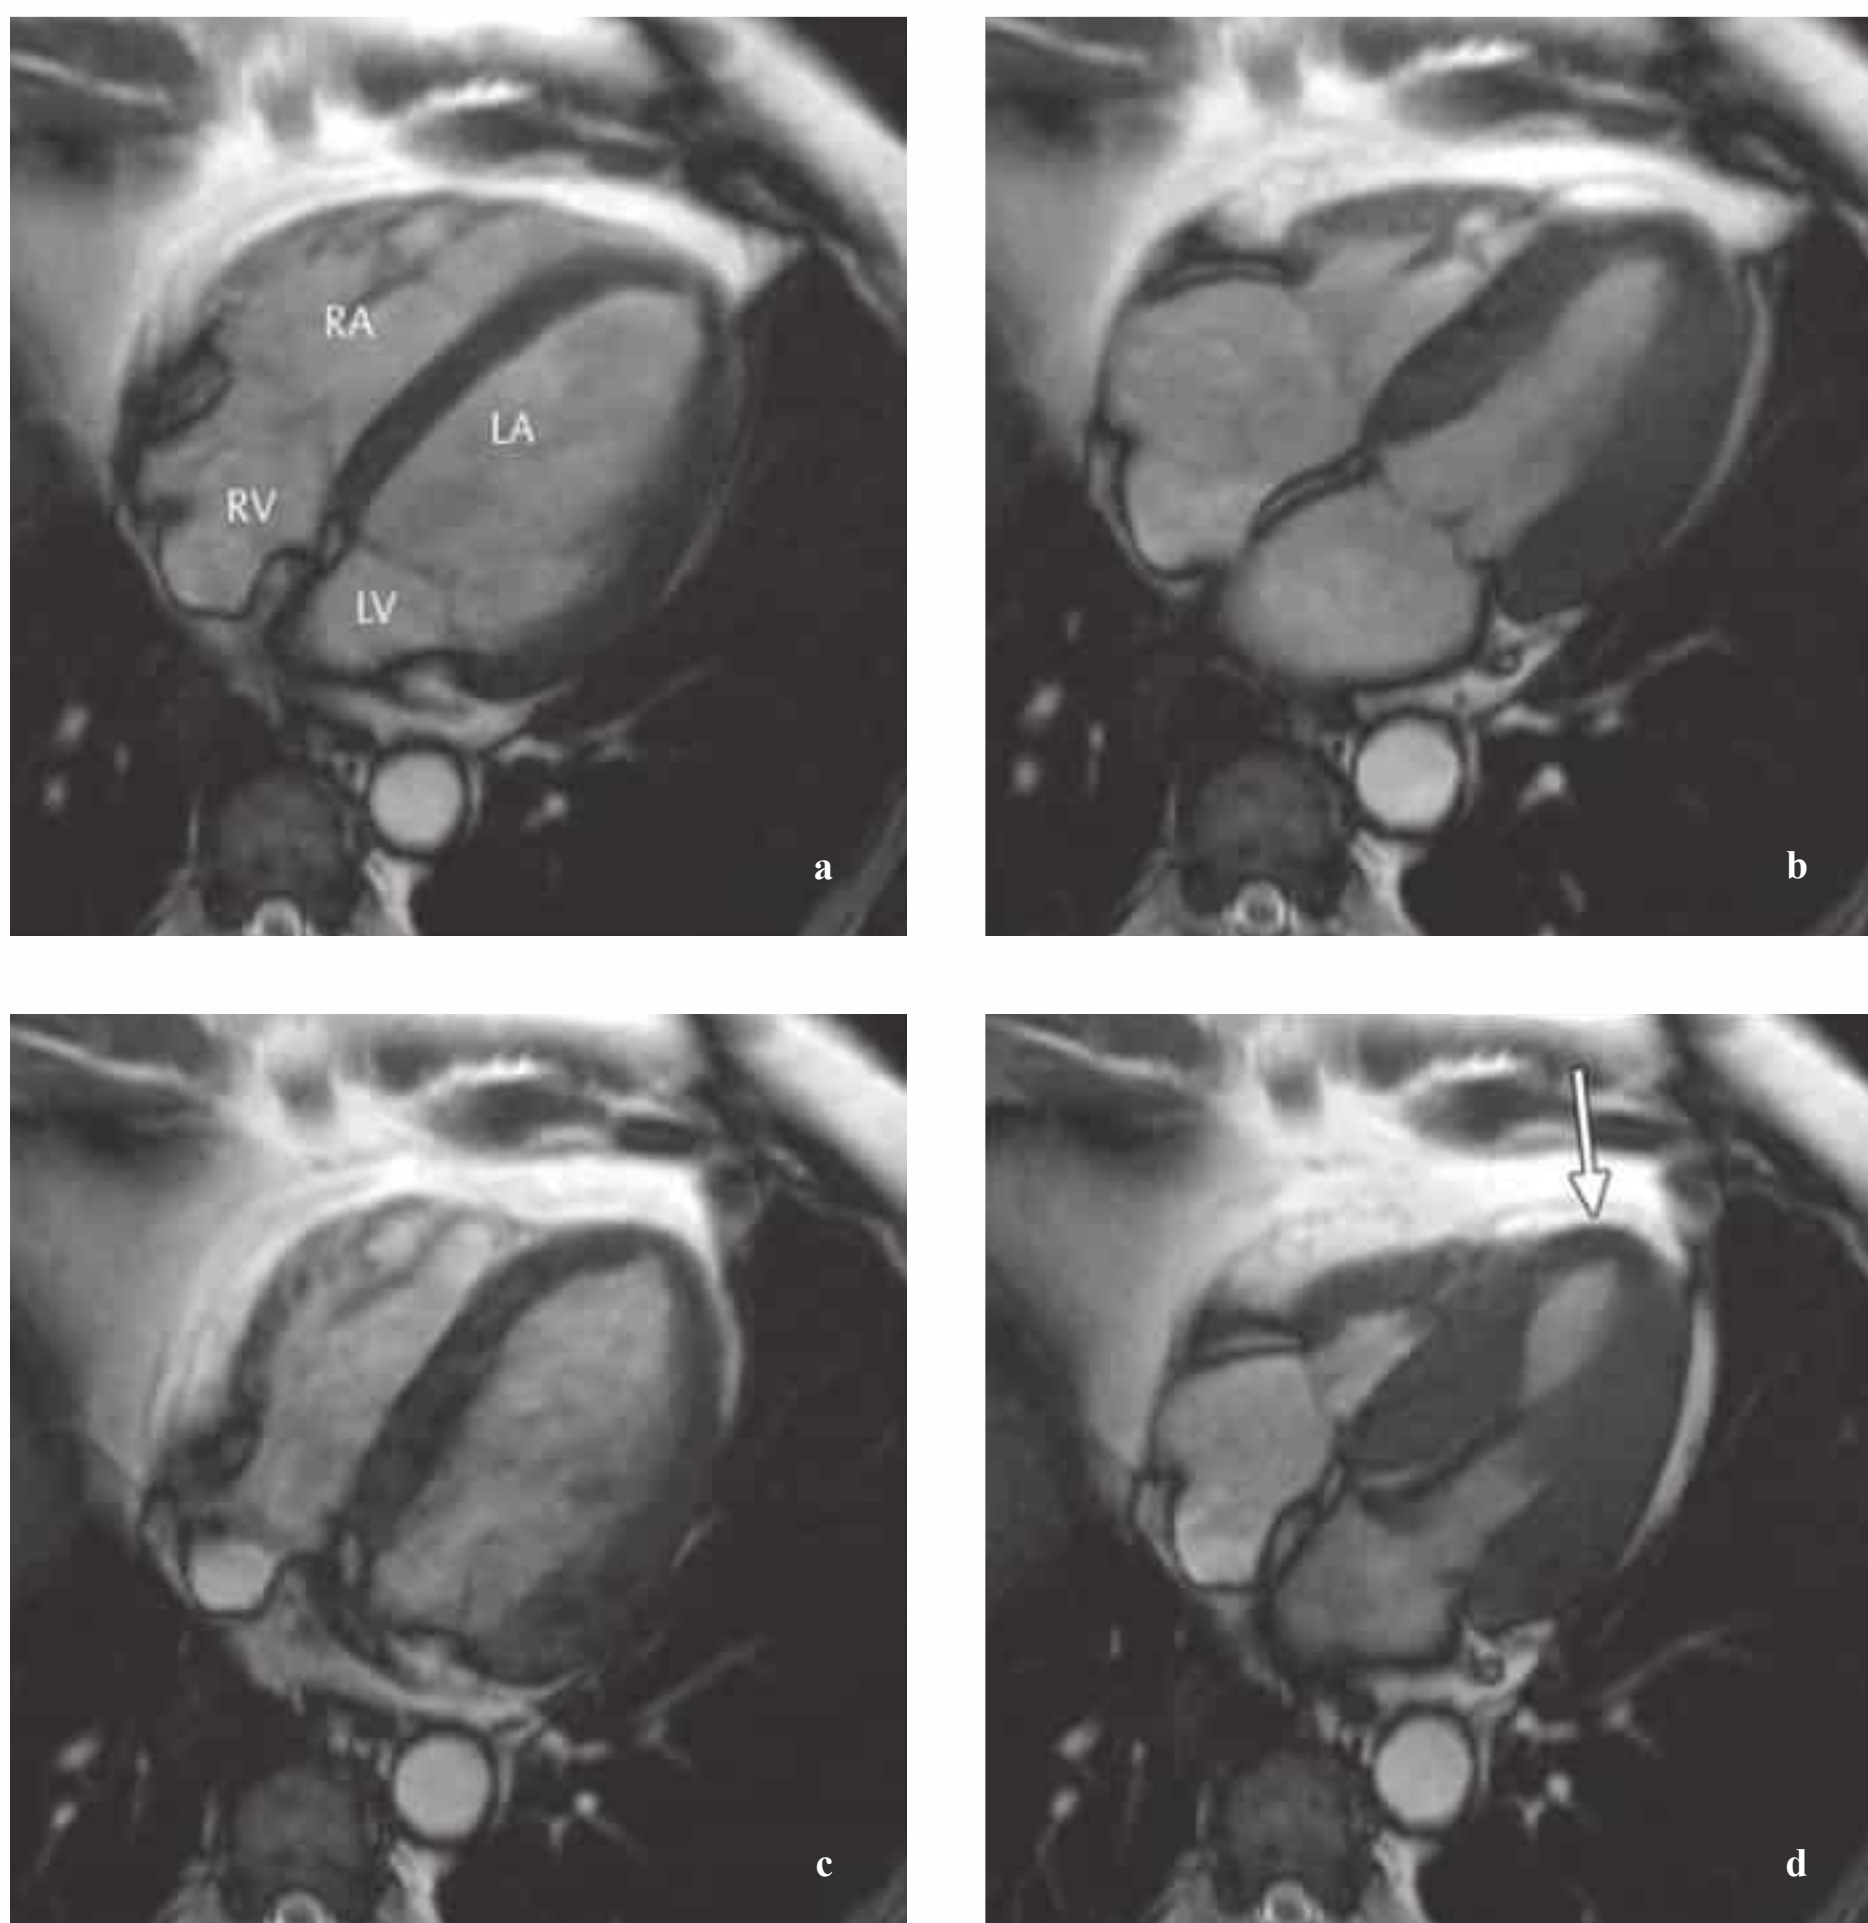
a–d Stress MRI in a patient with chronic ischemia due to high-grade LAD stenosis. Horizontal long-axis images of the LV acquired with a segmented SSFP cine sequence. Rest images at end diastole (a) and end systole (b) demonstrate normal regional and global wall motion. With high-dose dobutamine stress (40 $\mu\text{g}/\text{min}/\text{kg}$ bw), akinesia develops in the apical third of the septum and ventricular apex (arrow, AHA segments 14 and 17). The appearance of stress-induced WMA in two segments confirms the diagnosis of ischemia, caused in this case by a high-grade LAD stenosis.
